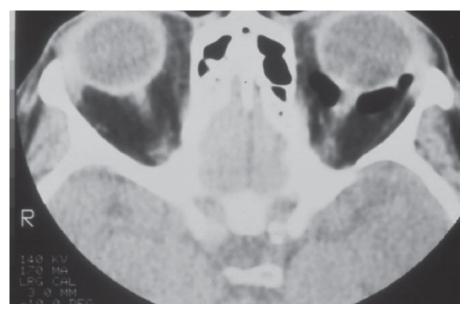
A CT image of the orbits in a patient with a left orbital floor fracture. Note the image void behind the left eye; this is air, and the retrobulbar orbit is contiguous with the maxillary sinus beneath due to the fracture.
